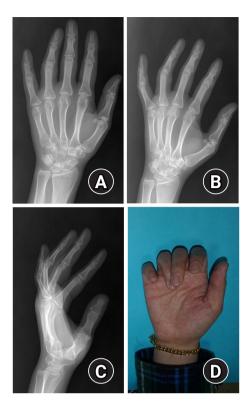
Proximal phalanx fracture of fourth finger with difference between X-ray findings and physical examination. Fracture of the proximal phalanx base of the fourth finger was shown with minimal displacement on the X-ray (A-C). However, finger overlap due to rotational displacement was observed on physical examination (D).
